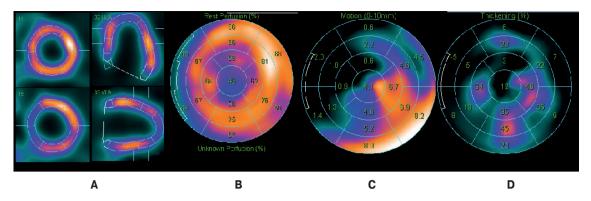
Initial myocardial perfusion SPECT in the patient with non-ischemic HF. A. Perfusion scintigrams. B. Polar map of LV perfusion. There is a diffuse uneven RP distribution, no reliable focal defects. Signs of small focal perfusion defects in the septal and inferolateral LV segments. C. Polar map of systolic LV wall motion. LV dilatation, diffuse hypo(a) kinesis of all LV walls, except for the inferolateral, up to dyskinesis of the anterior and septal LV segments. EDV of 139 ml, ESV of 97 ml, stroke volume of 42 ml, LVEF of 30% (N>50%) with heart rate of 117 bpm, cardiac output of 4,7 l/min. D. Polar map of LV systolic wall thickening. Systolic thickening of all LV walls is sharply reduced.
